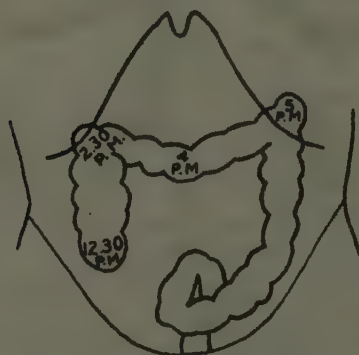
X-ray observation of normal colon in man and position attained by its contents at different periods after a meal containing bismuth. The bismuth meal was taken at 8 A.M. Times of arrival at different levels marked in colon. (*Herts.*)
